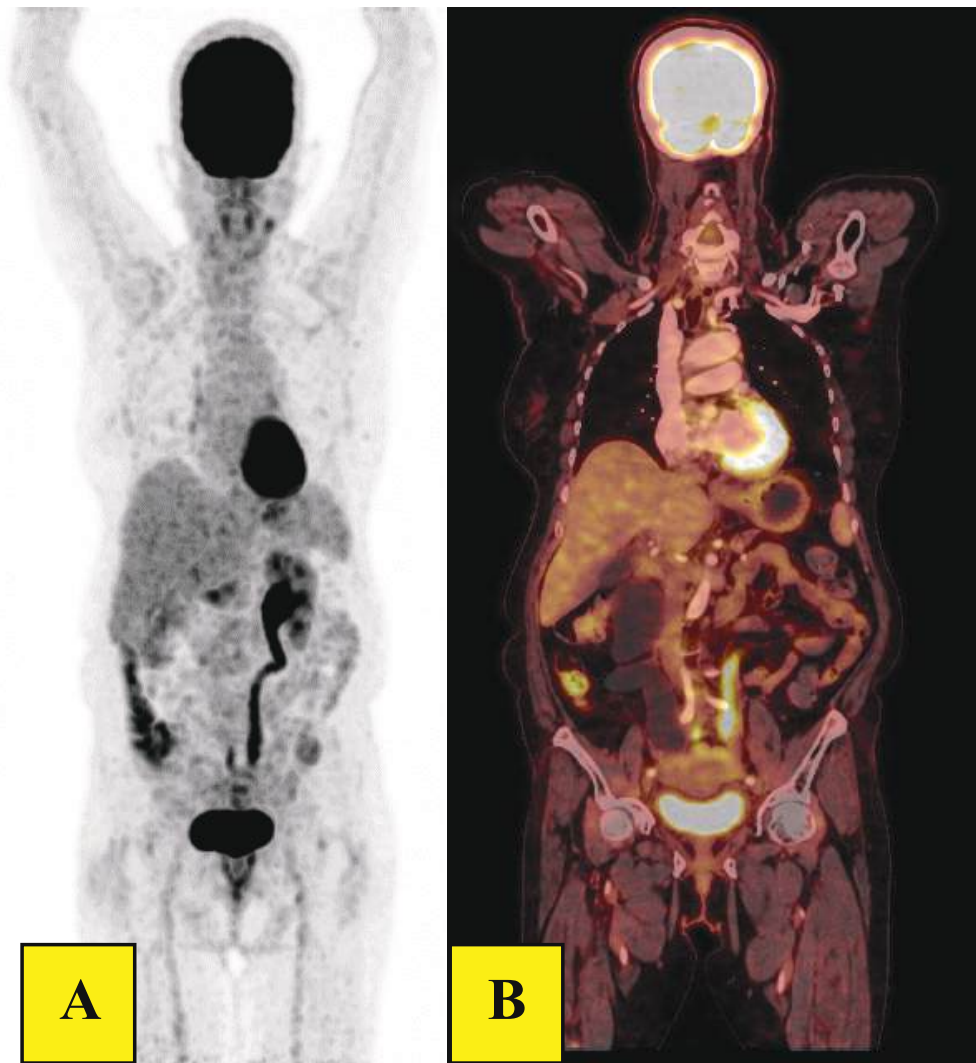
Whole body MIP PET/CT image (A) and coronal views of fused PET/CT images (B).
